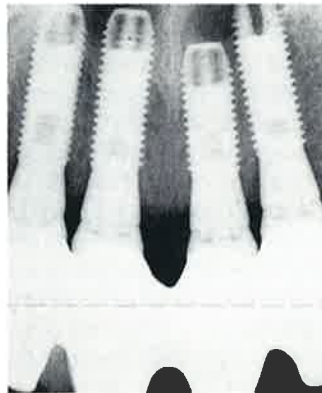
Periapical radiograph two years postop.
